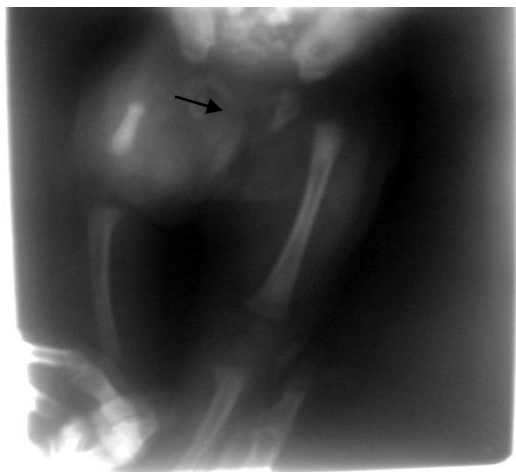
Plain X-ray showing hypoplastic right femur (black arrow) with delayed appearance of epiphyseal ossification around the right knee
